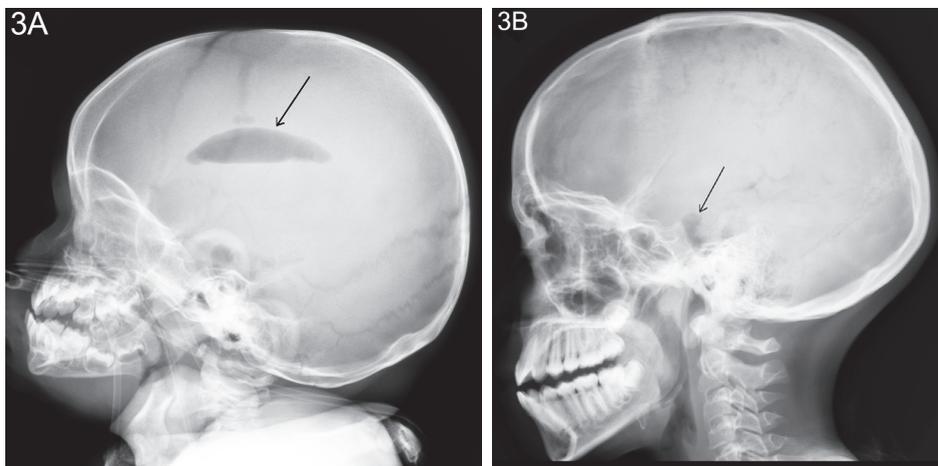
The lateral skull X-ray shows air in the basal cistern and lateral ventricles. This indicates communicating hydrocephalus (arrow) due to basal cistern obstruction to the flow of cerebrospinal fluid. 3B. The lateral skull X-ray shows only air at the level of the basal cistern (arrow). This indicates non-communicating hydrocephalus due to obstruction of the 4th ventricle outlet foramen.
